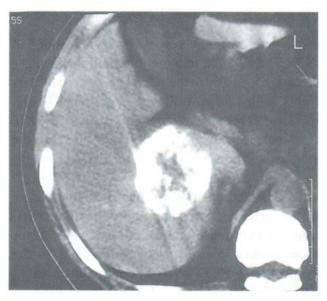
The computed tomography of abdomen, after injection of Lipiodol-I*131, showed dense Lipiodol I*131 in the periphery of the HCC.
